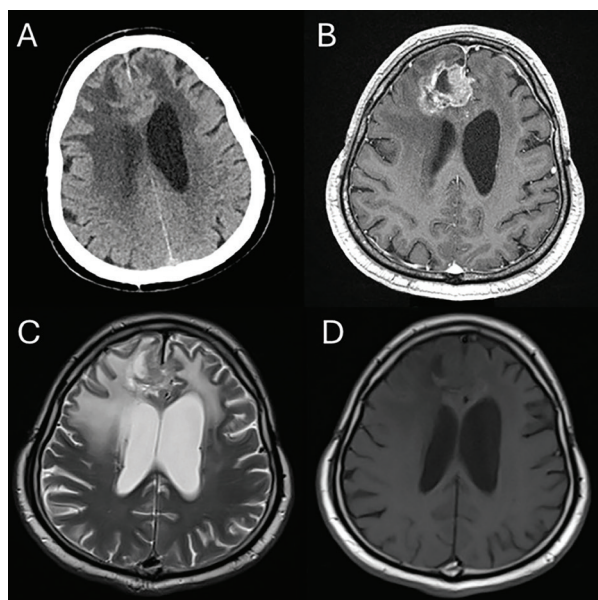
Preoperative images of the second surgery. Computed tomography (A), gadolinium-enhanced T1-weighted (B), T2-weighted (C), and T1-weighted magnetic resonance images (D) revealed a tumor with homogeneous contrast enhancement in the deep portion of the resection cavity
